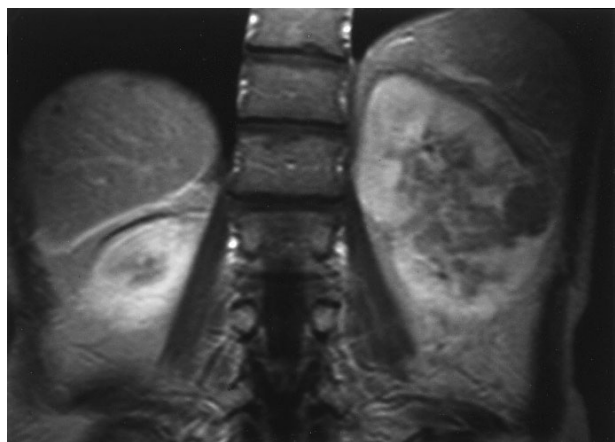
Contrast-enhanced T1-weighted image showed a nodule in the cortex of the left kidney. The medulla of the left kidney was hypointense compared with normal kidney tissue.
